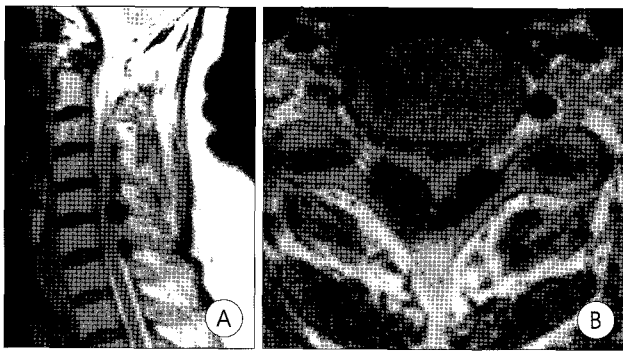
A : In magnetic resonance imaging of cervical spine, T2-weighted sagittal imaging(T2WI) shows an oval mass with hypointense signal in ligamentum flavum between C4-6. And it shows severely compressed spinal cord with intramedullary signal change in T2WI. B : Axial magnetic resonance image of cervical spine shows compressed spinal cord posteriorly by a hypointense signal mass in T2-weighted sagittal imaging.
